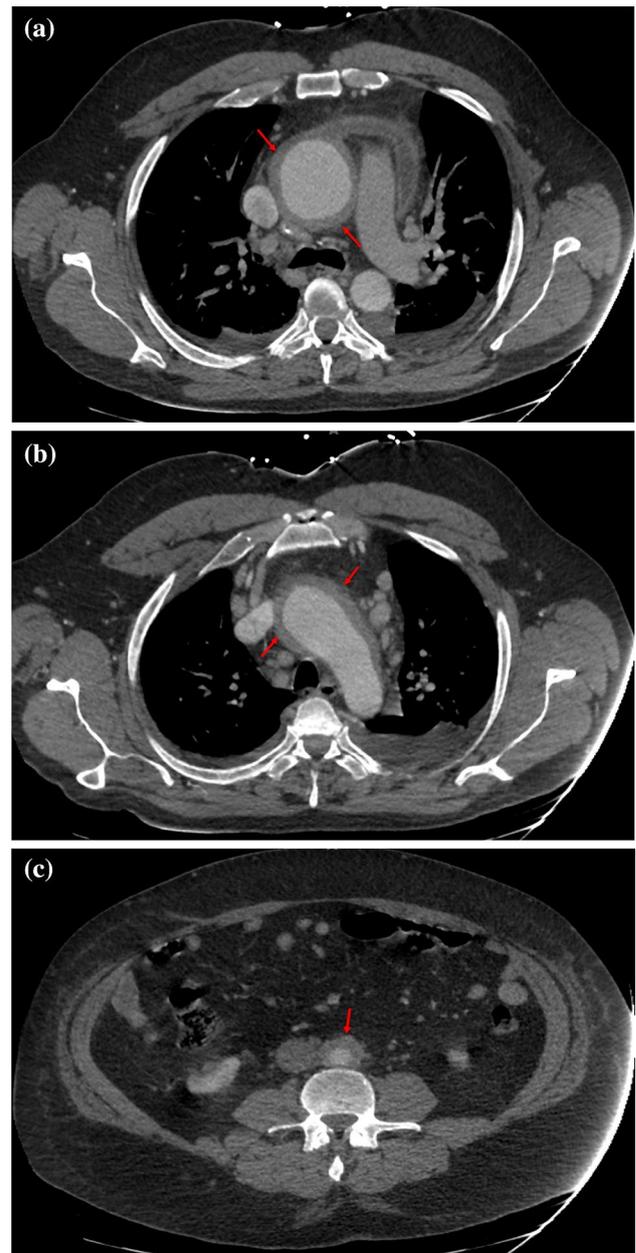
Transverse images of a CT angiogram of chest and abdomen revealing wall thickening of the a ascending aorta (8 mm), b aorta arch wall (8.8 mm), c abdominal aorta (10 mm)
